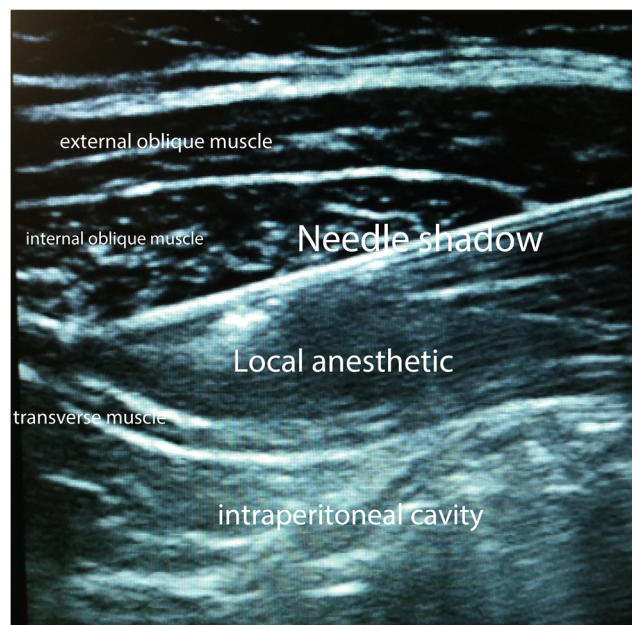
US-guided TAP block. Ultrasound image of the anatomical structures relevant for the transversus abdominis block. Local anesthetic is injected in-between the internal oblique and transverse abdominis muscle
